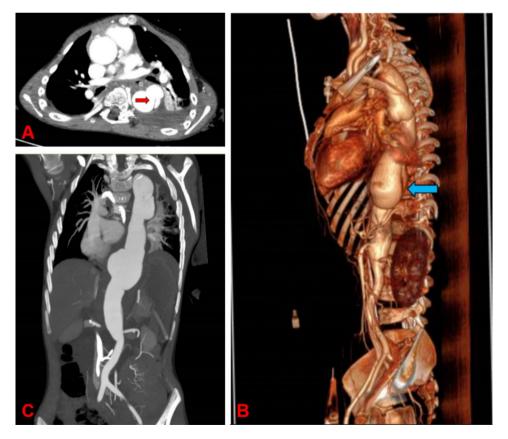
A) a large intimal fissure (red arrow). B) Preoperative 3-dimensional computed tomographic image showing the aortic dissection near the diaphragm (blue arrow) forming a huge hematoma around it. C) Marked dilatation of the thoracoabdominal aorta and formation of a huge aneurysm
